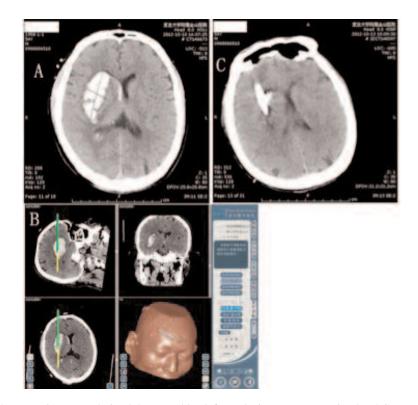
A male 54-year patient was admitted due to sudden left paralysis. *A*, Pre-operation head CT scanning showed hemorrhage on the right side of the basal ganglion, the volume of hematoma was approximately 22 ml, accompanied with mild compression of the contralateral cerebral ventricle. There is no shift of midline structures in the brain. *B*, Navigation during operation. *C*, Three days after operation, CT scan showed that drainage was nearly achieved.
